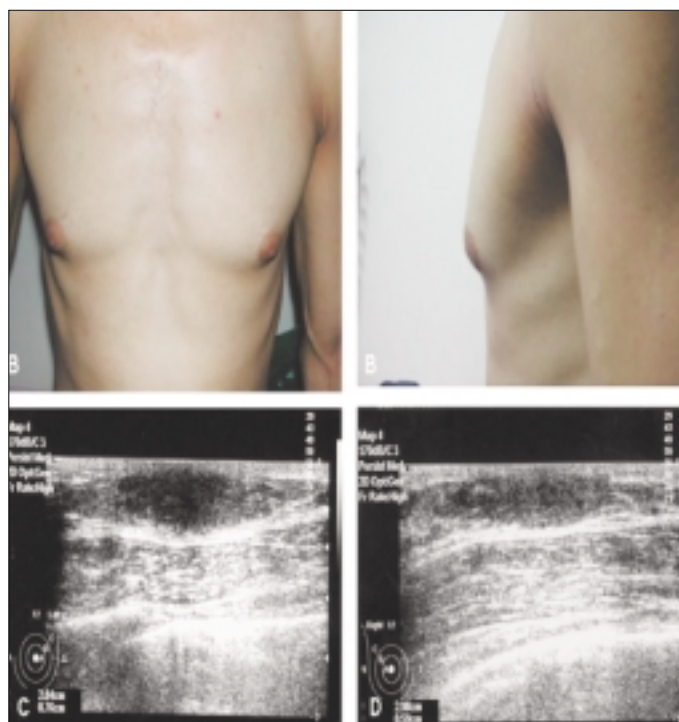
Bilateral gynaecomastia of the patient (a and b: on the physical examination; c: left breast and d: right breast by ultrasound) In ultrasound examination, the spindle-shaped increased amount of breast parenchyma shows homogenous echoes
